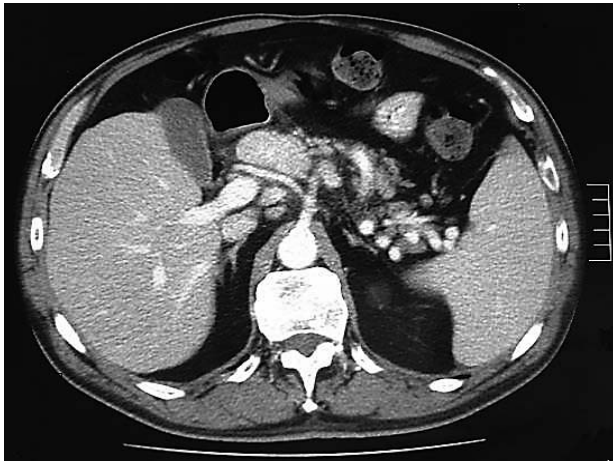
Computed tomography scan showing a 4 cm mass with a necrotic centre and a significant contrast enhancement near the trifurcation of the celiac axis and very close to the hepatic artery.
